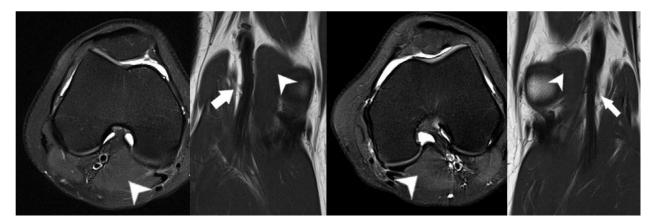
Routine bilateral knee MRI. Axial PD FAT Sat and Coronal T1 images of the bilateral knees demonstrate an hypertrophy of an otherwise normal medial gastrocnemius muscle bilaterally (arrowheads) which leads to mild narrowing and medial displacement of the popliteal artery bilaterally (arrows).
